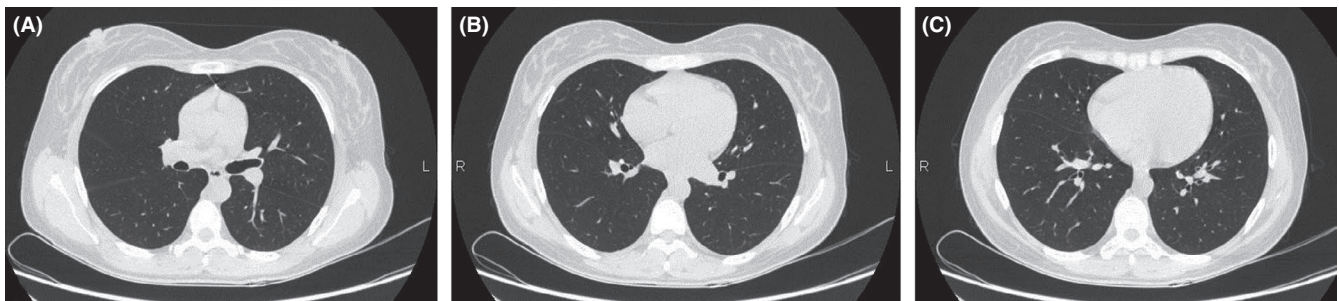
The CT scans show normal pulmonary parenchyma
